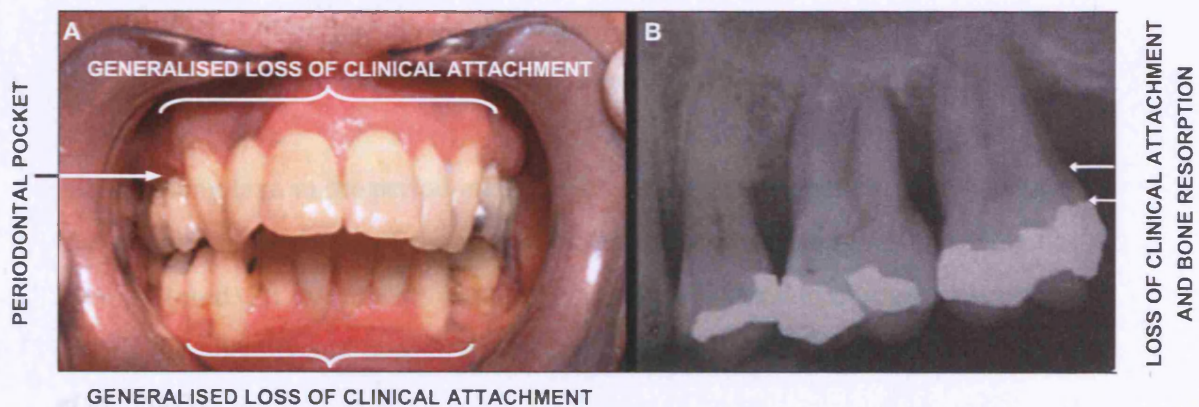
(A) Clinical photograph of generalised chronic periodontitis (GCP): In a patient older than 30 years of age, periodontitis in this case is not confined only to the incisors and first molars. (B) Radiograph of GCP. Demonstrating bone resorption associated with molars and pre-molars (photographs kindly provided by Luigi Nibali)
